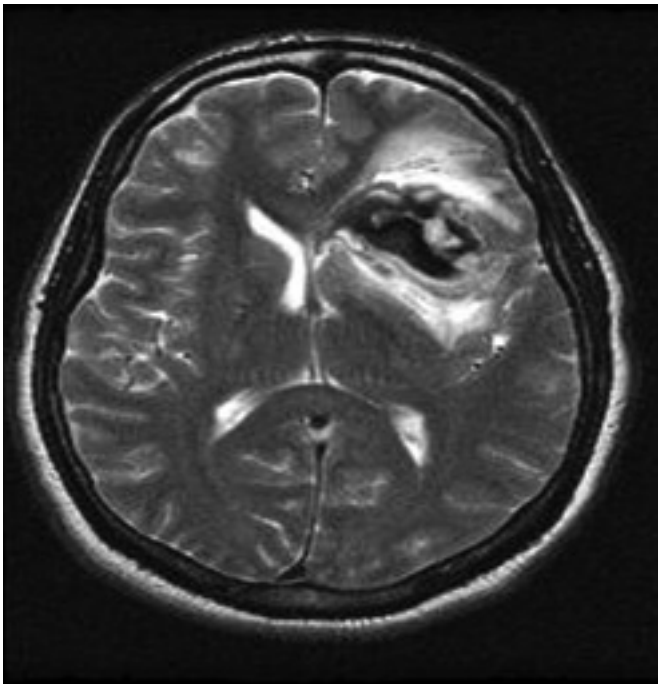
Pathophysiology of sSICH. The T2 weighted MRI demonstrates a subacute deep intracerebral hemorrhage with surrounding "hyper intensity". Mechanisms leading to perihematomal neural injury and deficits include: mechanical disruption and compression, ischaemia, edema, biochemical and inflammatory processes and hematoma expansion.
